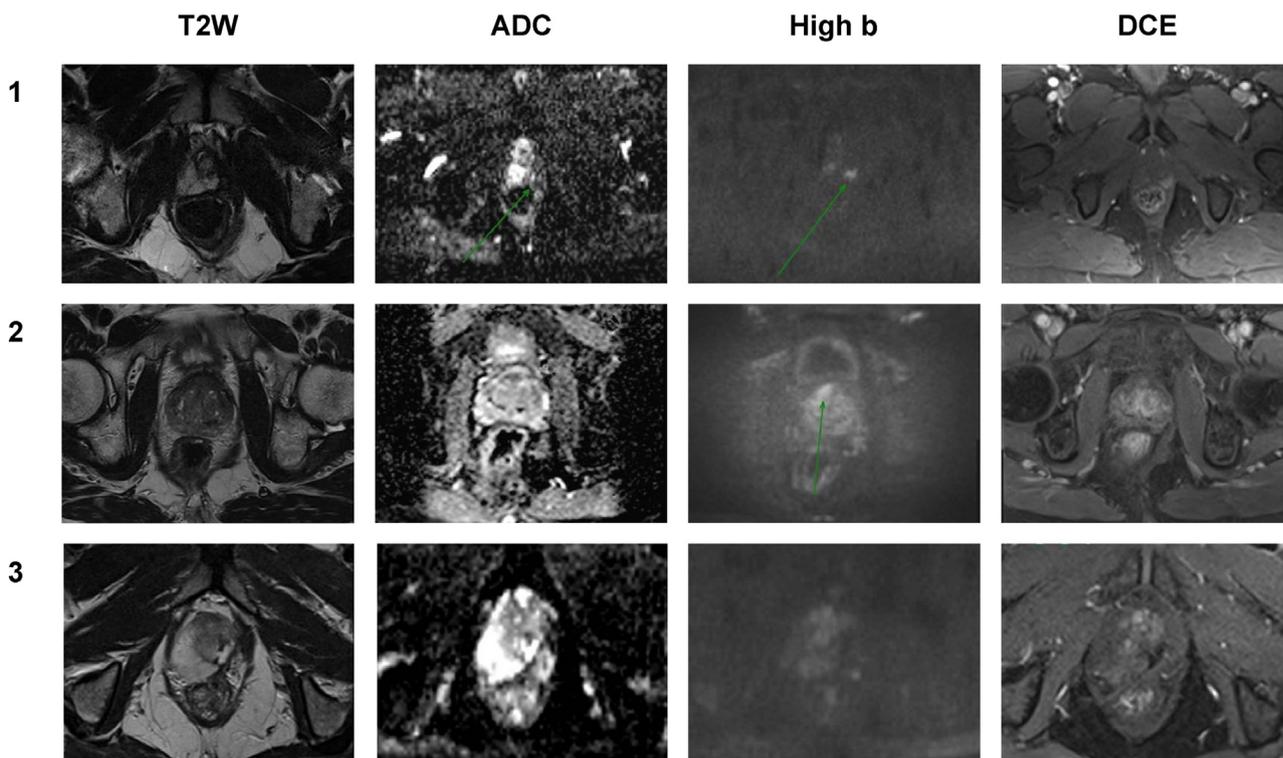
(A) Recommended 5-point magnetic resonance imaging scoring system for assessment of lesions within the ablation zone after focal therapy for prostate cancer. The DCE sequence is the major sequence and the DWI and T2W sequences are joint minor sequences. The overall score should be interpreted as follows: 1 = very low suspicion; 2 = low suspicion; 3 = equivocal; 4 = high suspicion; and 5 = very high suspicion. Each sequence should be individually assessed with a score out of 3. Criteria for DCE interpretation are given in the adjacent table. No agreement could be reached for specific criteria for DWI and T2W interpretation. During discussions on DWI it was suggested that a focal high signal on high b-value images could be suggestive of recurrent tumour and this may be more reliable than using ADC maps to identify restricted diffusion. For T2W sequences, a low to intermediate signal that is slightly higher than for fibrotic tissue but lower than for untreated tissue could be deemed more equivocal and possibly suspicious. Comparison should be made to DWI and DCE findings. (B) Examples of MRI scans after focal therapy with varying findings within the ablation zone. Row 1: MRI performed 20 mo after left-quadrant ablation with HIFU. At the posterior aspect of the left apex, there is a focal lesion with restricted diffusion on ADC and high-b images (DWI 3/3), with corresponding early enhancement (DCE 3/3). This would give an overall score of 5/5. Targeted biopsy of this lesion was positive for seven of 12 cores, revealing grade group 3 cancer with a maximum cancer core length of 12 mm. Row 2: MRI performed 43 mo after right-quadrant ablation with cryotherapy. At the anterior aspect of the right transition zone there is a lesion with restricted diffusion on the high b-value image (DWI 3/3), but no contrast enhancement (DCE 1/3). This would give an overall score of 2/5. Targeted biopsy of this lesion was negative for all six cores sampled. Row 3: MRI performed 18 mo after left-quadrant ablation with HIFU. There is no diffusion restriction (DWI 1/3) or contrast enhancement within the ablation zone (DCE 1/3), giving an overall score of 1/5. Template biopsies sampling the whole prostate were all negative. ADC = apparent diffusion coefficient; DCE = dynamic contrast-enhanced; DWI = diffusion-weighted imaging; HIFU = high-intensity focused ultrasound; T2W = T2-weighted.
